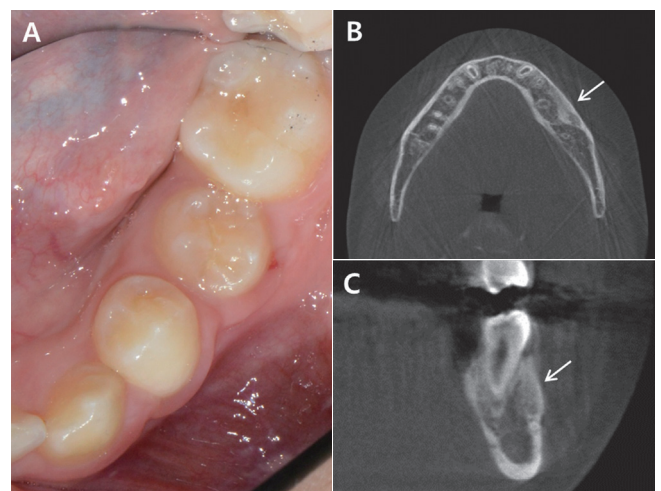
At 4 months after the procedure, the affected tooth erupted spontaneously (A). CT axial view (B) and coronal view (C) at 7 months after the procedure show a diminished lesion and new bone filling (white arrow).
